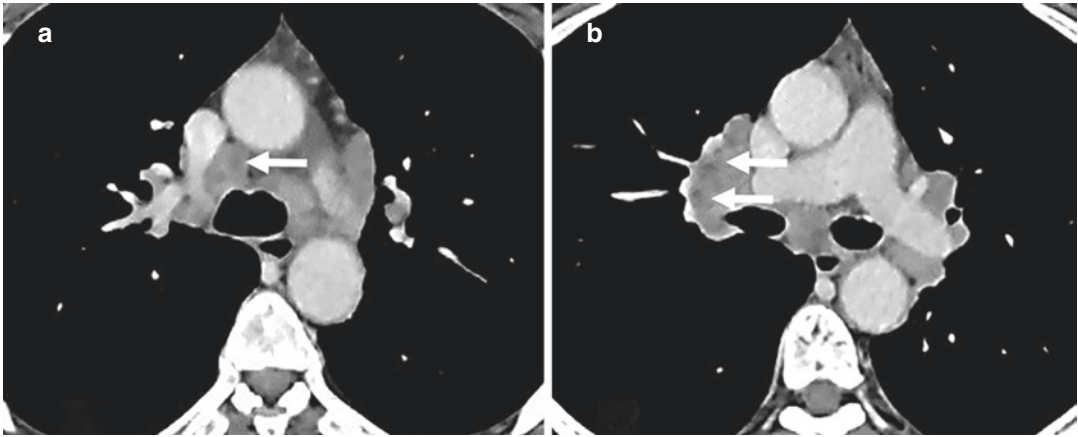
Sarcoidosis mediastinal lymphadenitis. (a and b) Axial contrast-enhanced CT images show heterogeneous enhancement of enlarged mediastinal lymph nodes with the “cluster of black pearls” sign (arrows)
